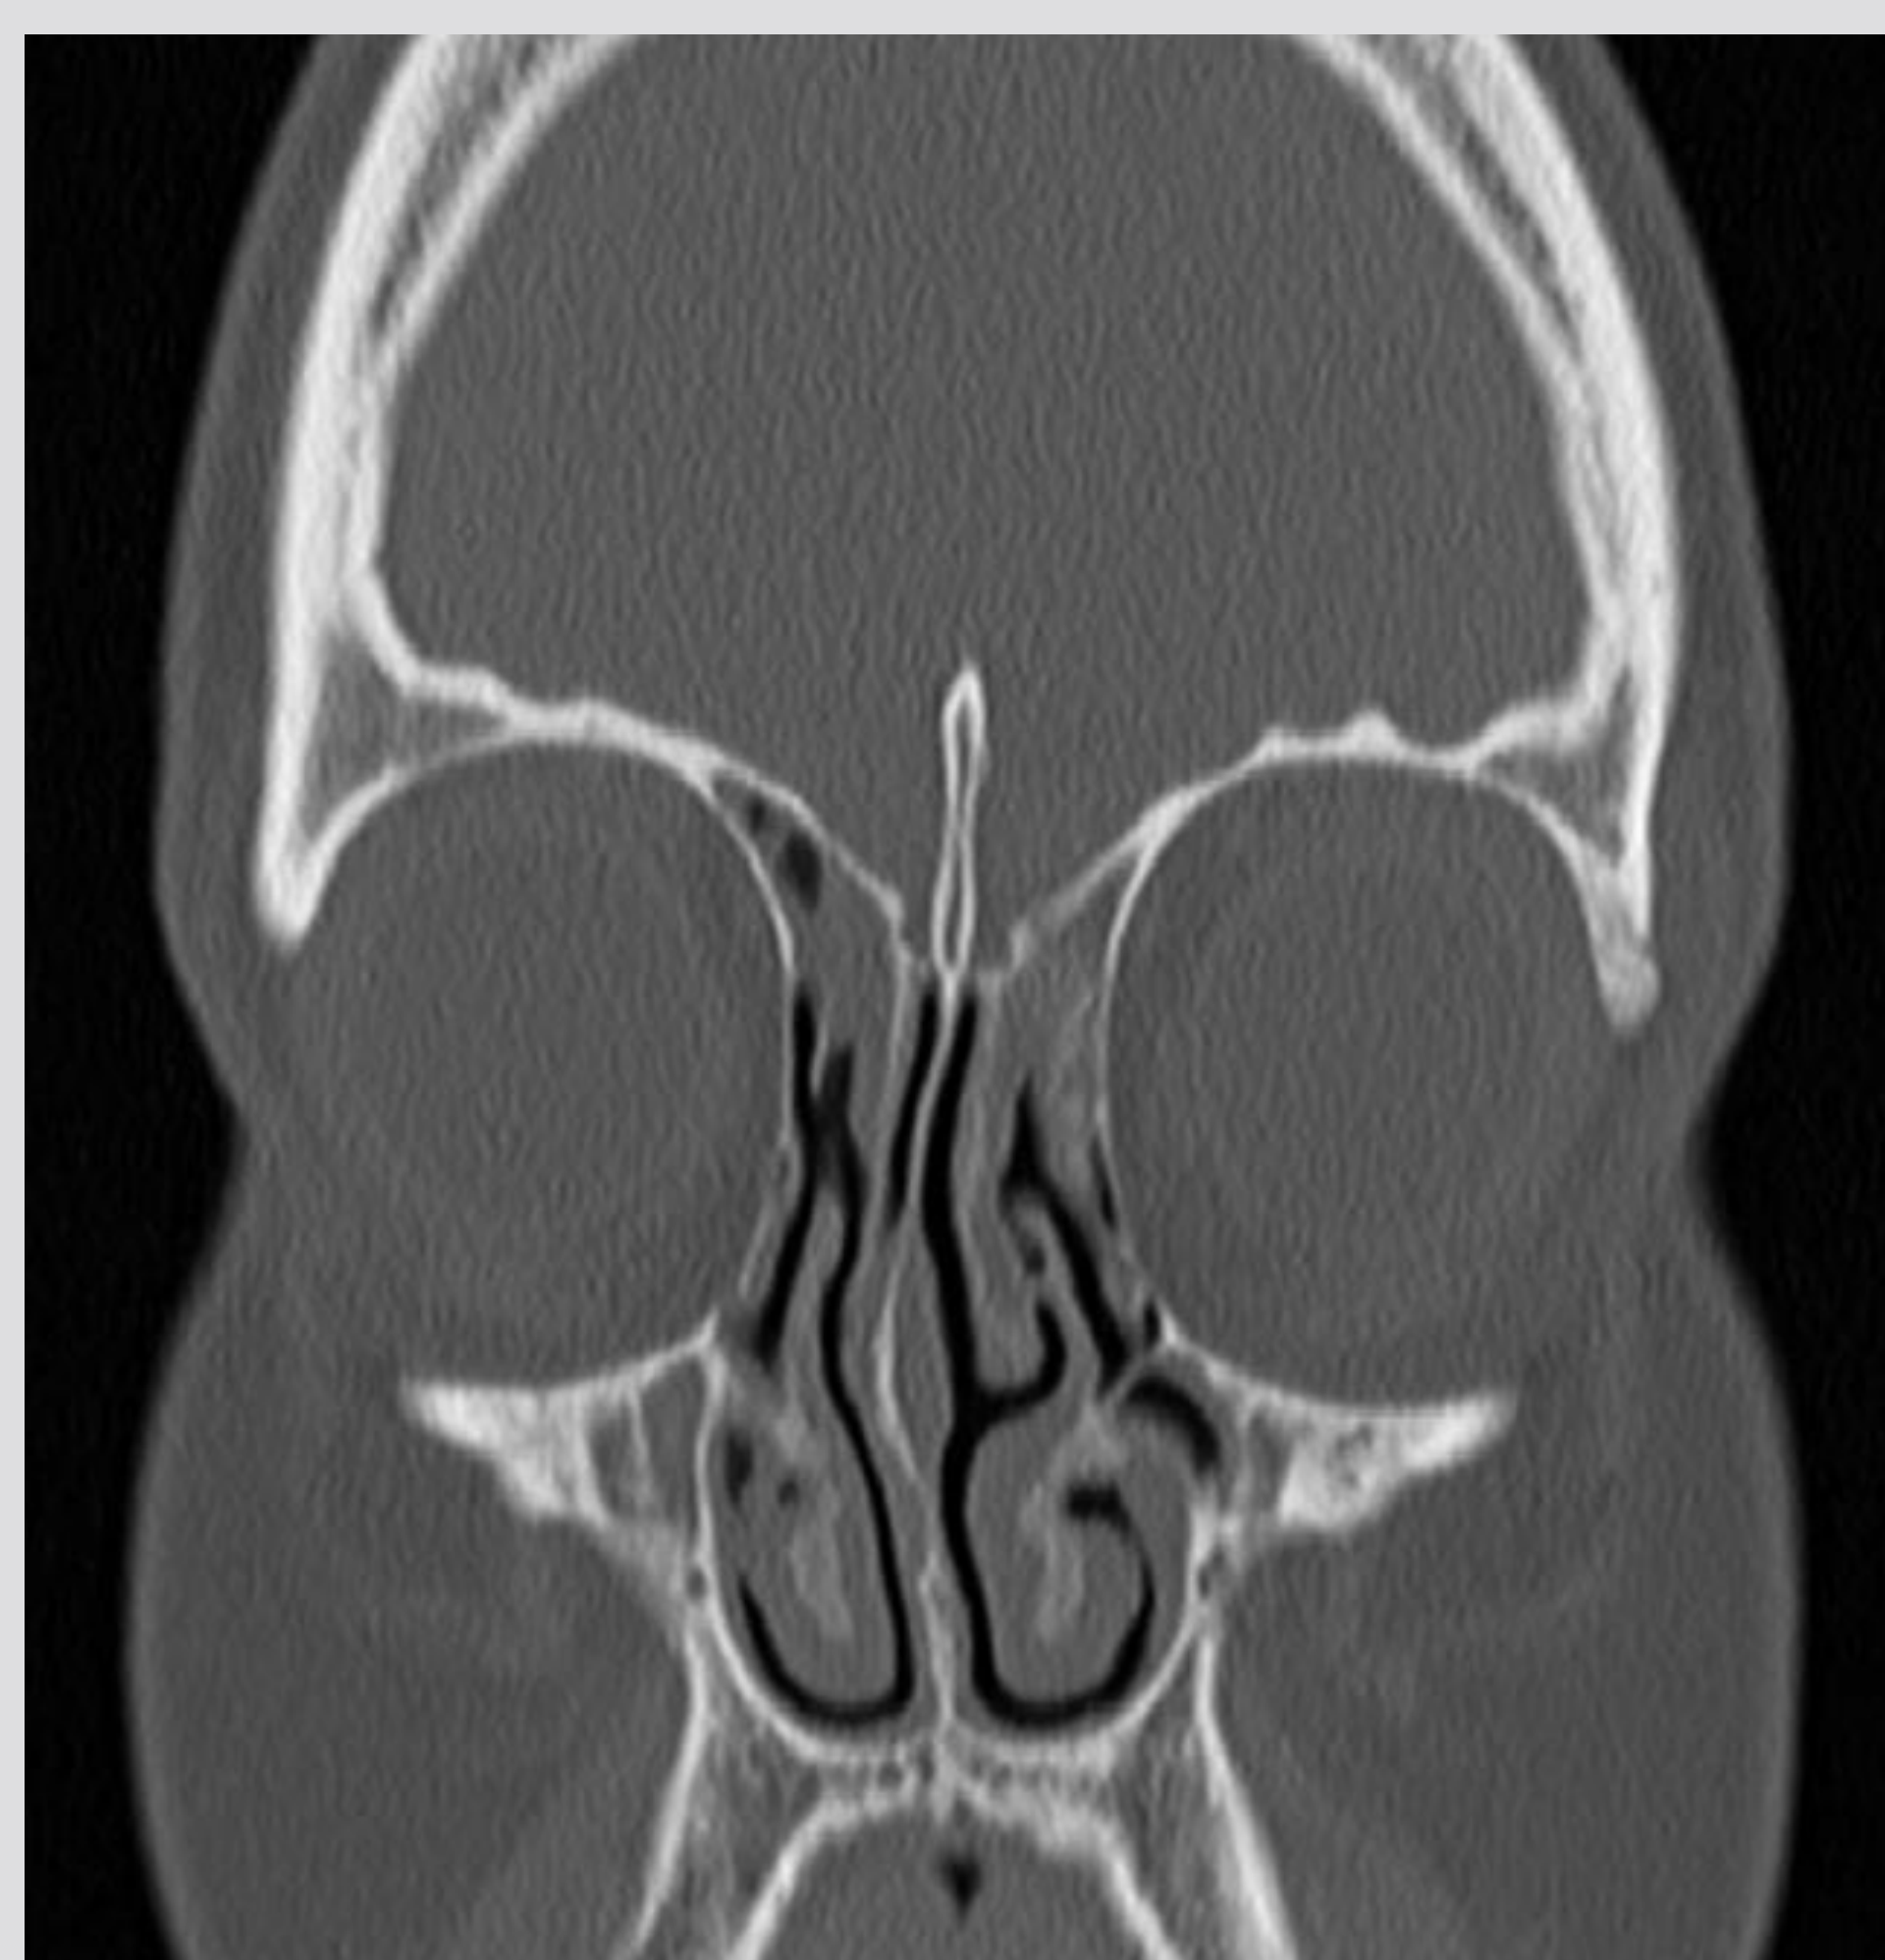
Coronal CT scan of the sinuses in a patient with CF
